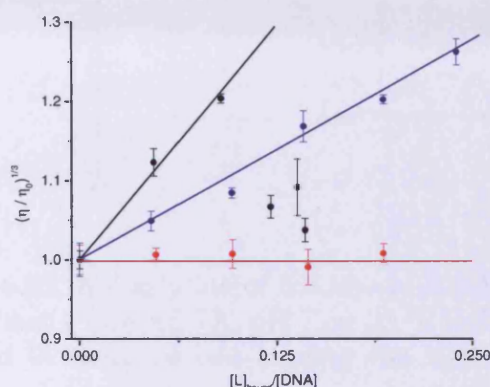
Relative viscosity of a 0.5 mM CT DNA solution upon addition of 5.4 (●), H33258 (●) and ethidium bromide (●) at 25 °C in 25 mM MOPS pH 7.0, 50 mM NaCl, 1mM EDTA.
